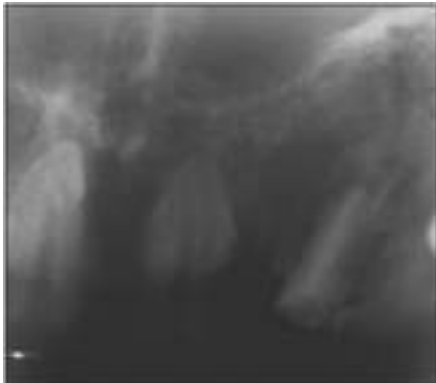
6 Month Post Operative Radiograph
